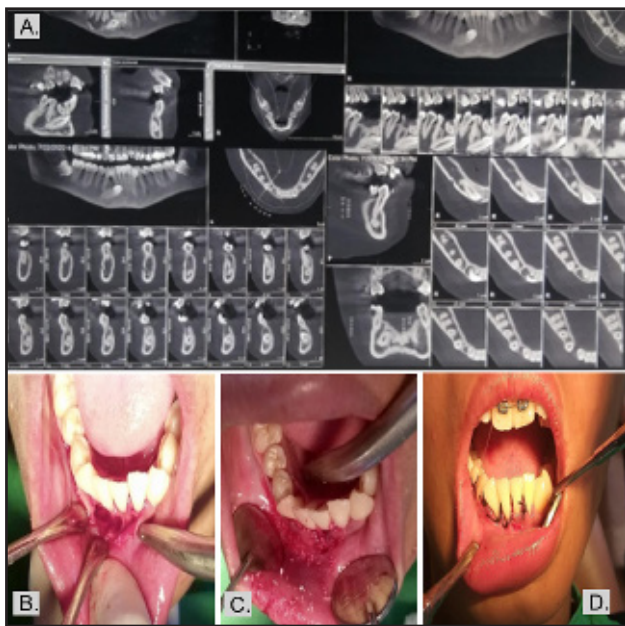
(A) Preoperative CBCT View, (B) Extraction socket site, (C) Bone grafting done, (D) Flap placement in its original position.
